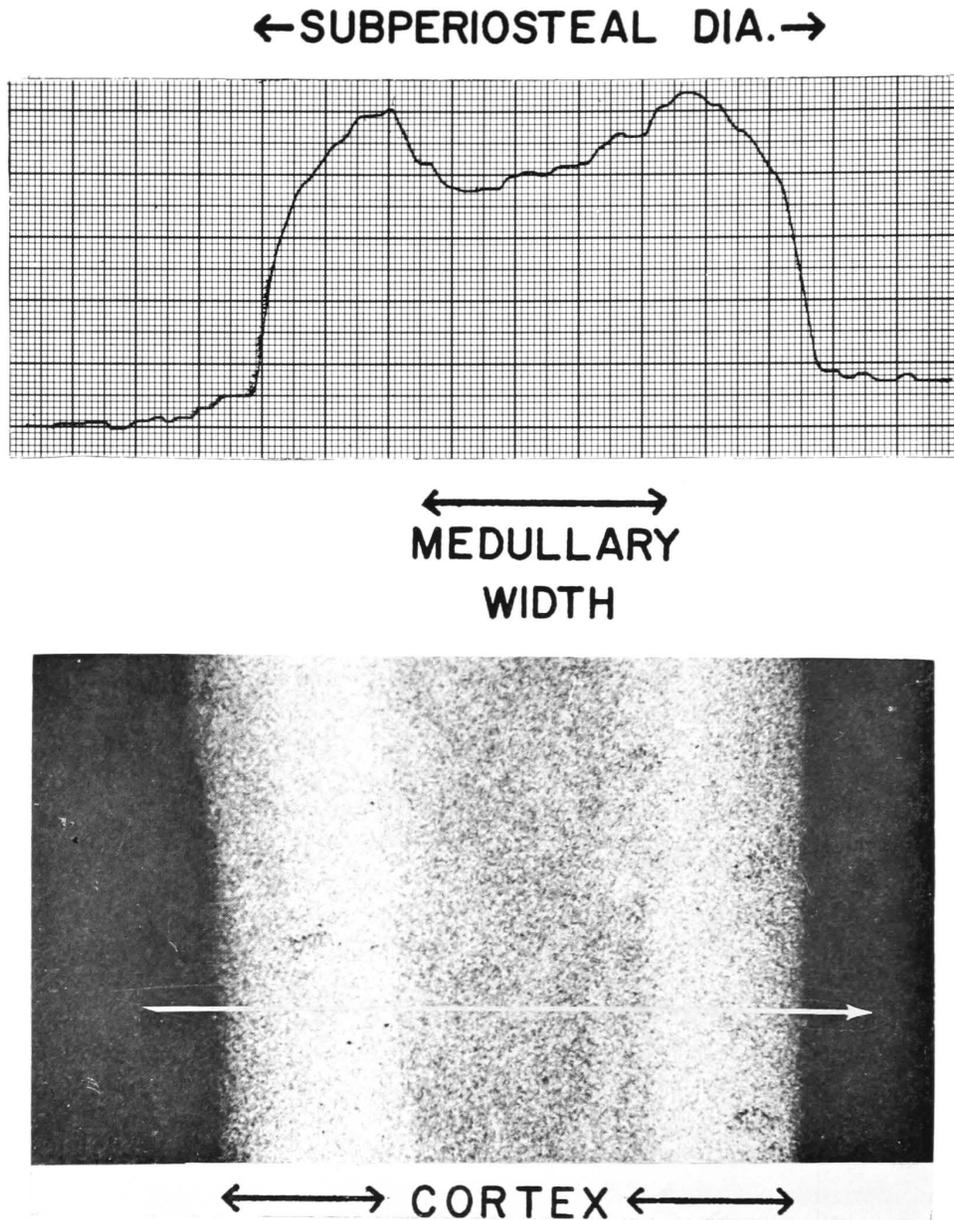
Comparison of microdensitometric trace (above) and radiographic image (below) of 2nd metacarpal traced at midshaft with the Joyce, Loebl recording microdensitometer. Measurements T and M can be made on the microdensitometric trace (Cf. Garn, Feutz, Colbert, and Wagner, 1966, Figures 2 and 3 and Table II).
